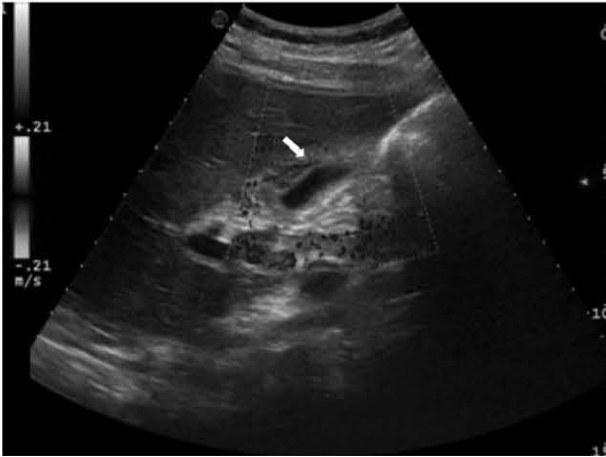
Increased color Doppler wall flow at the abdominal POCUS performed at admission.
